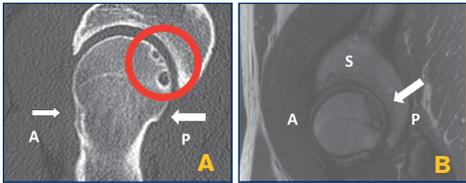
CT scan (2A) showing early osteoarthritis with subchondral cystic changes (circle) involving the posterior-superior head and cam deformity in the anterolateral (thin arrow) and posterosuperior (thick arrow) head neck junction. MRI sagittal view (2B) demonstrating an osteochondral lesion of the posterior-superior margin of the femoral head with cystic resorption of subchondral bone and basilar delamination of cartilage with separation at tidemark (arrow). A: anterior; P: posterior; S: superior
